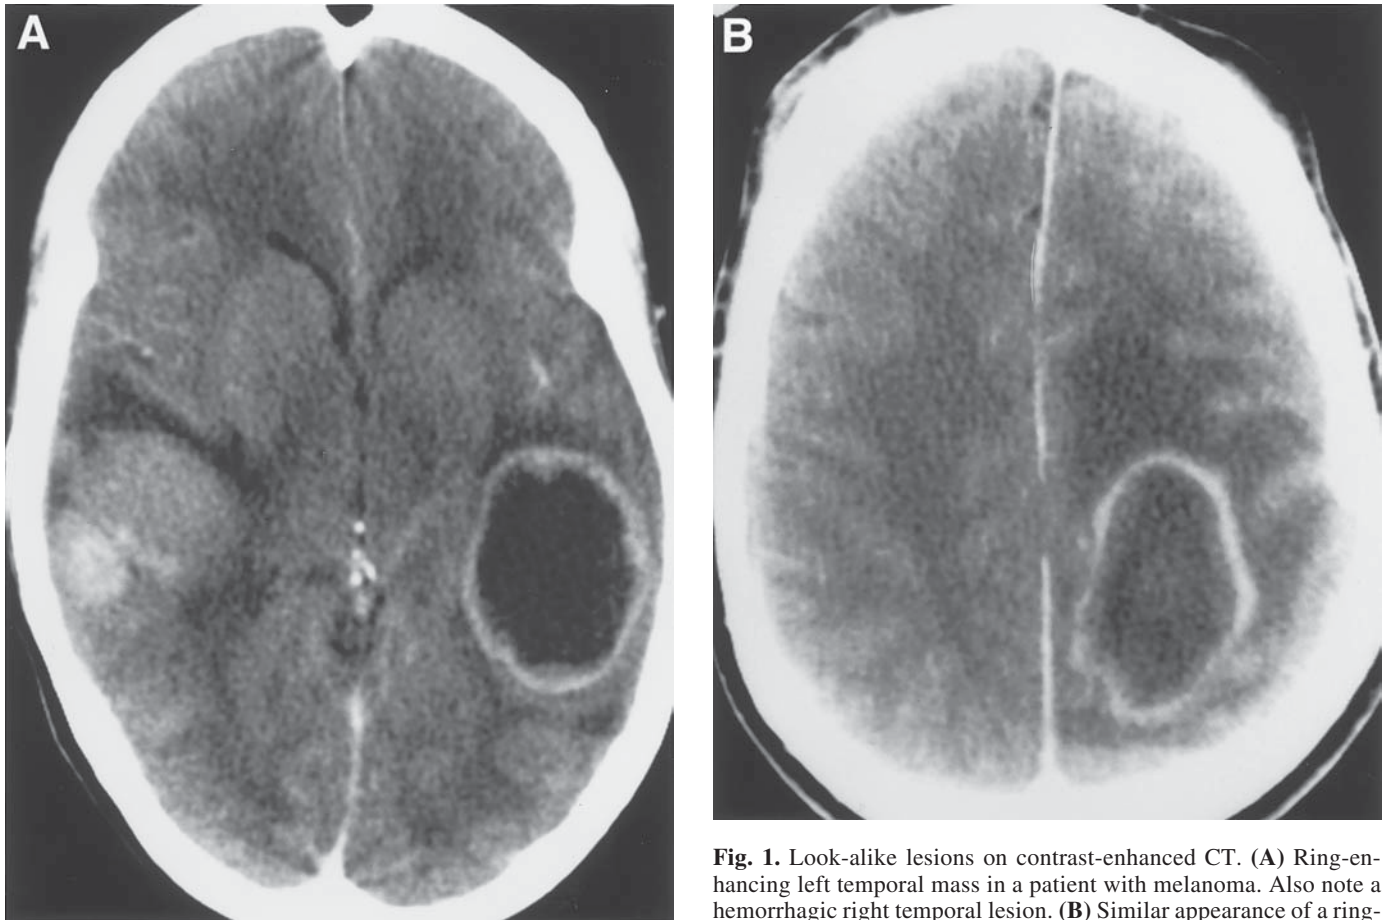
Look-alike lesions on contrast-enhanced CT. (A) Ring-enhancing left temporal mass in a patient with melanoma. Also note a hemorrhagic right temporal lesion. (B) Similar appearance of a ring-enhancing left parietal mass in patient presenting with right-sided numbness, hemiplegia, and aphasia. CT-guided drainage confirmed pyogenic material.
